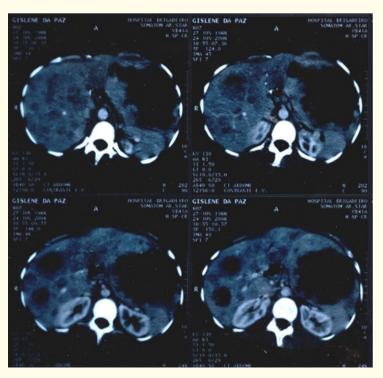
CT scan with liver metastases before the pregnancy.
